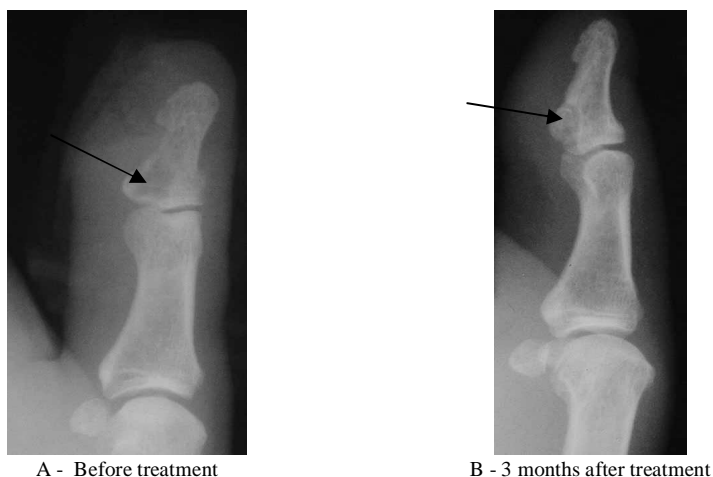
Change of roentgenologic picture of osteal panaritium in the patient X., 47 y.o.
